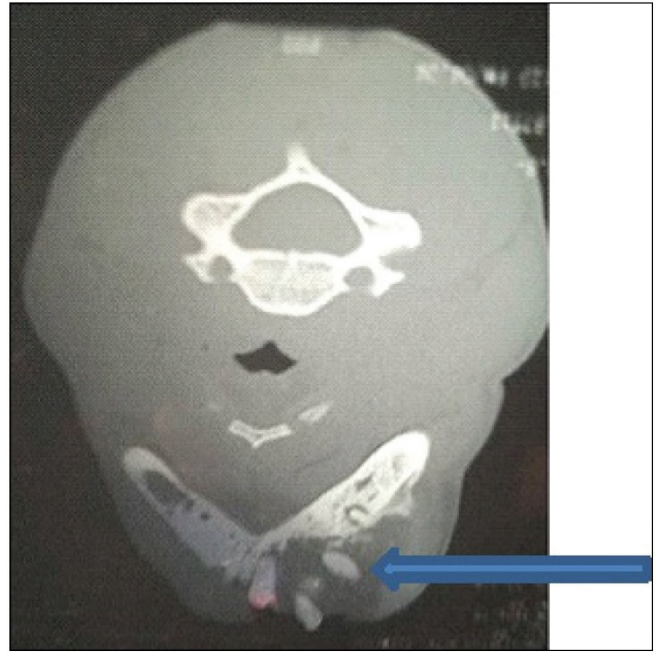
CT scan showing a unilocular radiolucent lesion and loosening of teeth (arrow)
